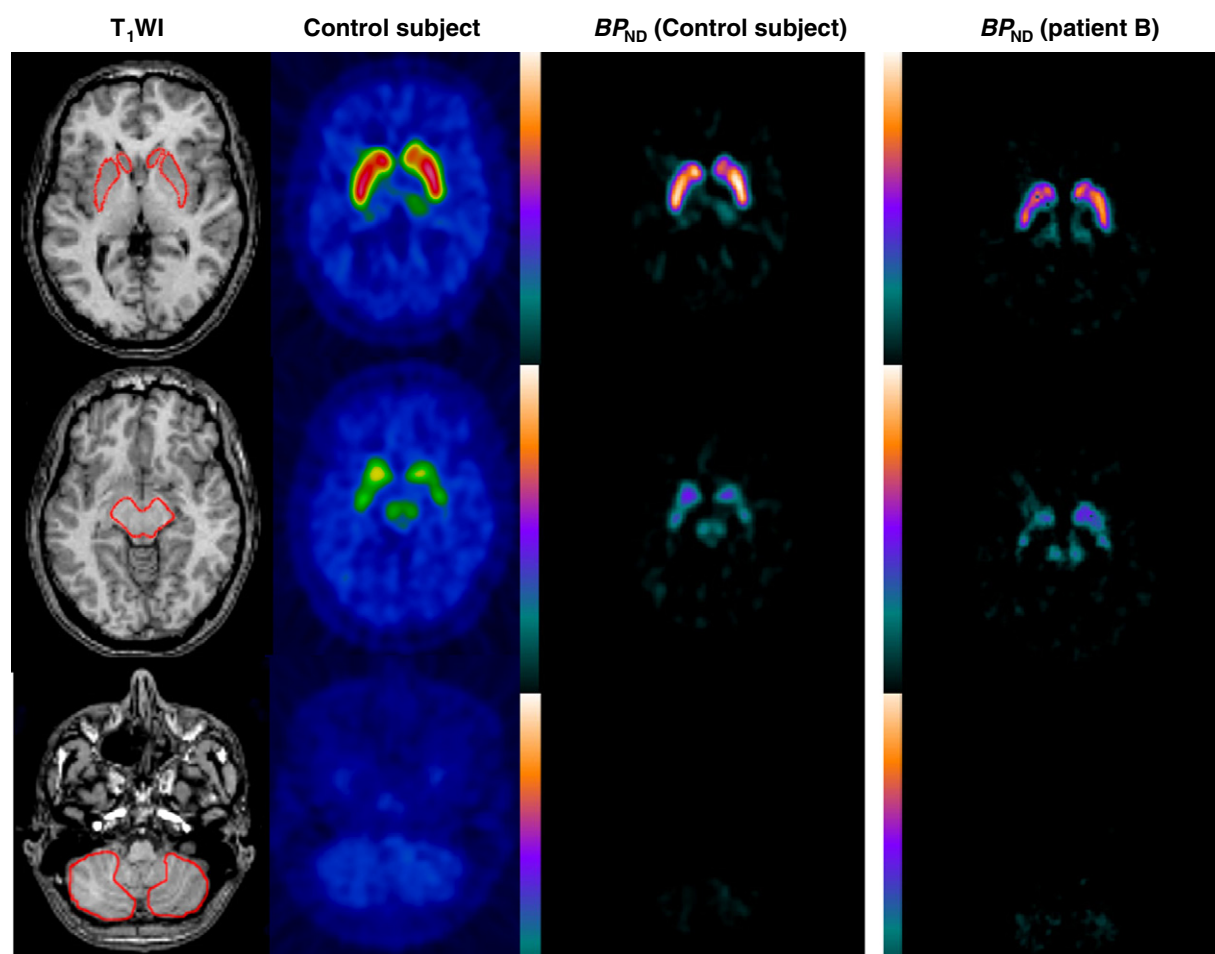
The summation images of [^{11}C]PE2I after i.v. injection, MR images and BP_{ND} images of a representative control subject, and BP_{ND} images of 45-year-old man with JME (patient B). The regions of interest were manually drawn on the putamen, the caudate, the midbrain and the cerebellum. No normalization was performed. BP_{ND} images were obtained by the automated receptor imaging system (ARIS).
